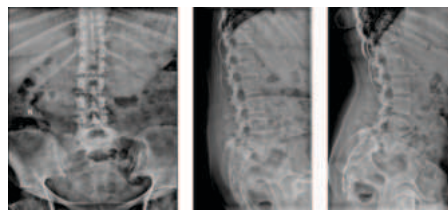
Pre-Operative X-ray of LS Spine AP view, Lateral view in flexion and extension
